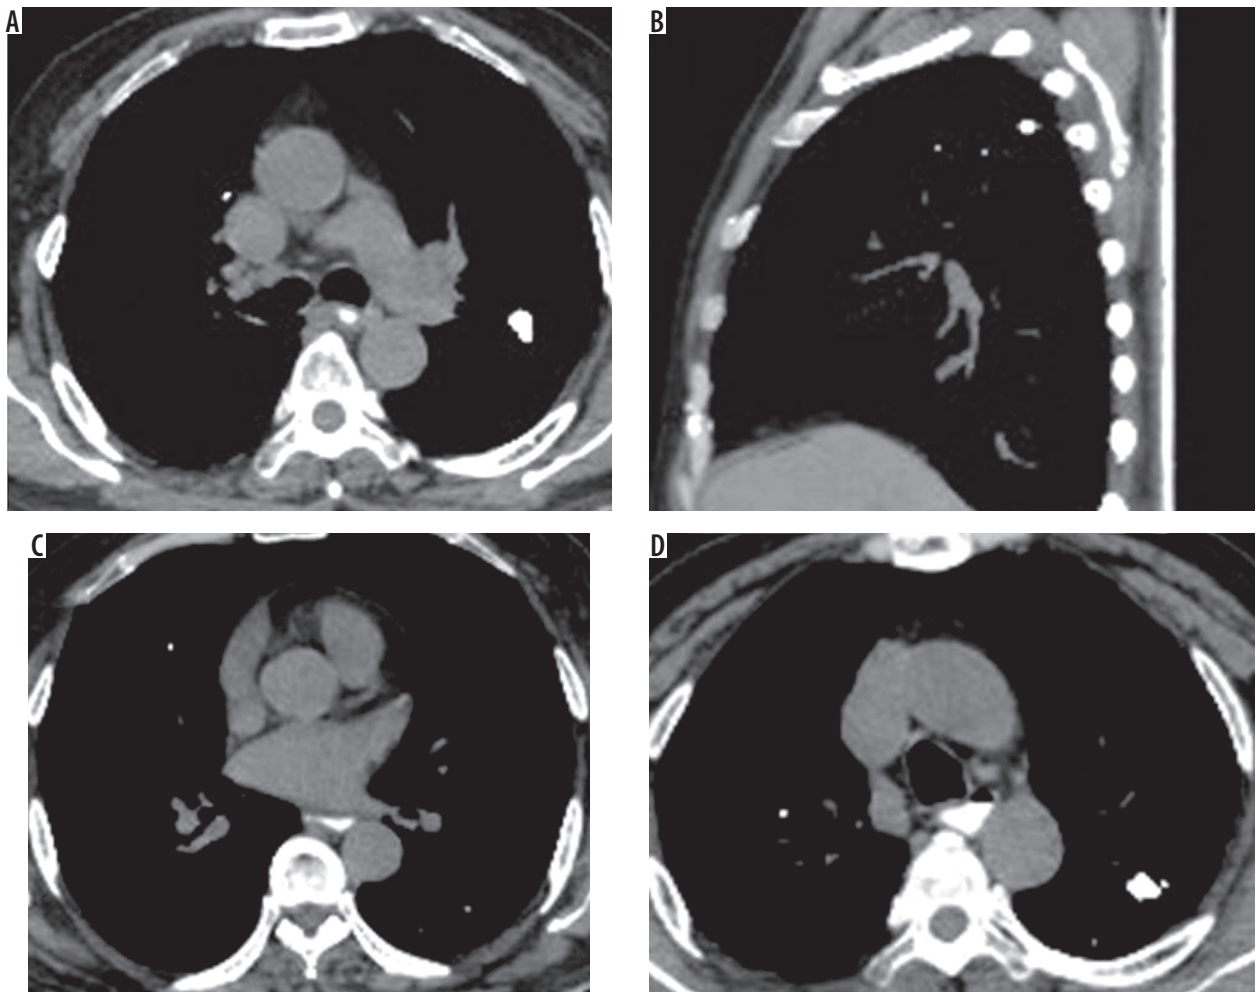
A-D) Axial plain chest computed tomography image mediastinal window showing multiple calcified nodules in both lungs showing diffuse calcification suggesting benign aetiology
